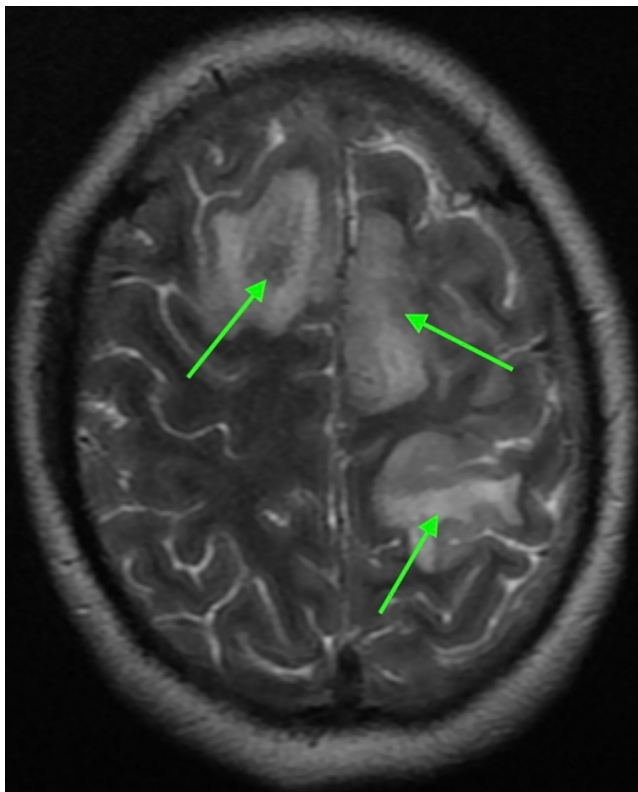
MRI showing the hemorrhagic transformations (shown by the green arrows).
